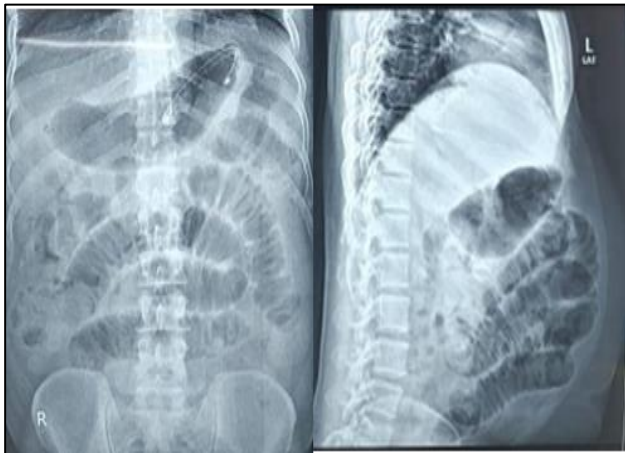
X-Ray abdomen showing dilated bowel loops.
